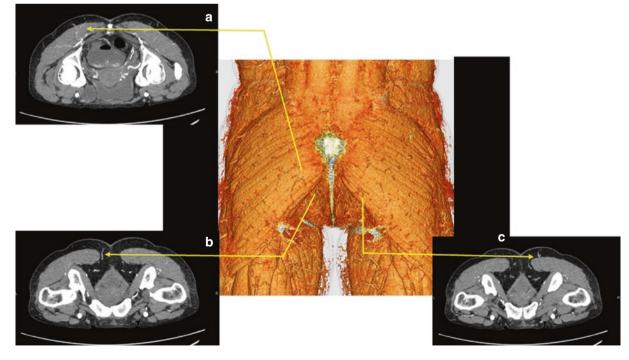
Computed tomographic angiography. (a) Two musculocutaneous perforators from inferior gluteal vessel are identified at the medial portion of the left gluteal maximus muscle. (b) One septocutaneous perforator identified from margin of the left gluteal maximus muscle. (c) One musculocutaneous perforator from inferior gluteal
